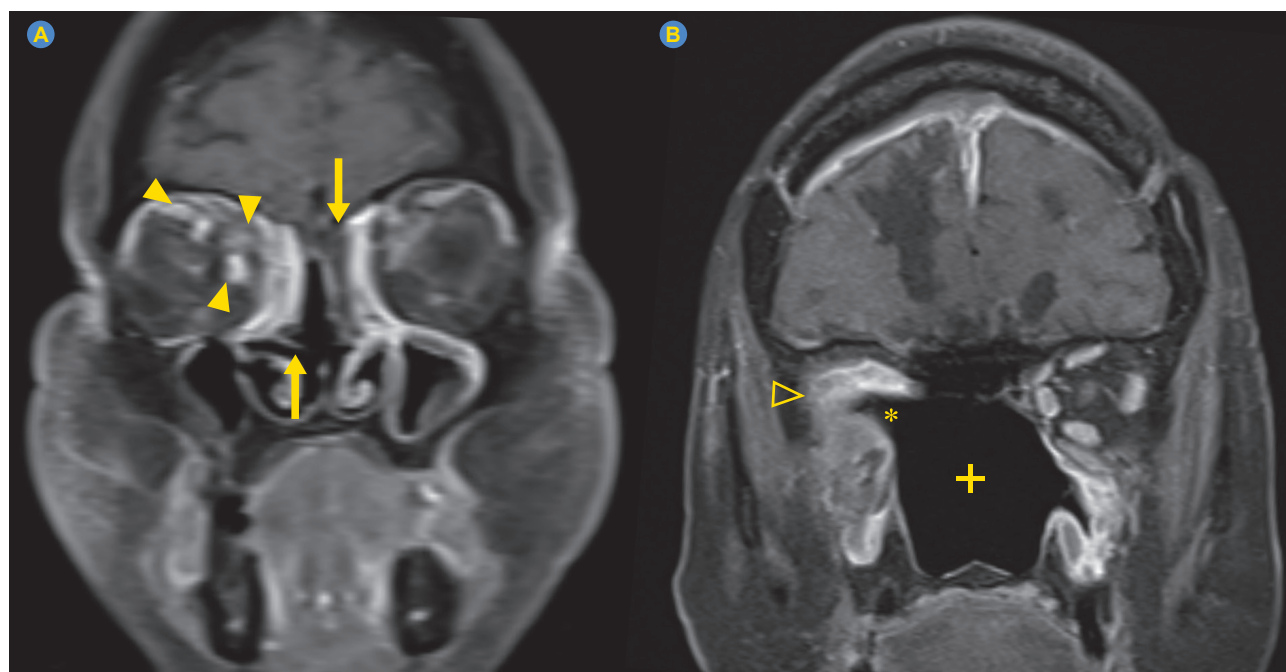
Magnetic resonance imaging (MRI) at diagnosis, coronal post-contrast T1 Dixon Water-Only (A). Extensive inflammatory/infectious filling of the ethmoidal air cells and the superior parts of the nasal cavities, and maxillary sinus mucosal thickening. Notably, there is minimal or no contrast enhancement of the nasal mucosa, as well as the middle turbinates, known as the ‘black turbinate sign’ (indicated by arrows), in regions of low signal on T2 STIR (not shown) which is suggestive of acute invasive fungal rhinosinusitis. Right orbital involvement is seen reflected by signal abnormalities of the intraorbital fat alongside edema (on T2 STIR, not shown), thickening and increased contrast uptake of the medial and superior rectus and superior oblique muscles (indicated by arrowheads). Additionally, there is evidence of slow flow of the superior ophthalmic vein. Follow-up MRI (1 year later), coronal post-contrast T1 Dixon Water-Only (B), reveals the extent of surgical interventions: right orbital exenteration (indicated by asterisk), total and bilateral ethmoid-maxillo-sphenoidectomy, turbinate and nasal septum resection (indicated by plus sign), and bilateral resection of the gyrus rectus with bifrontal cranioplasty. Residual inflammation is noted in the right orbital compartment (indicated by open arrowhead) and fronto-basal region, but there are no signs of an active infectious process.
